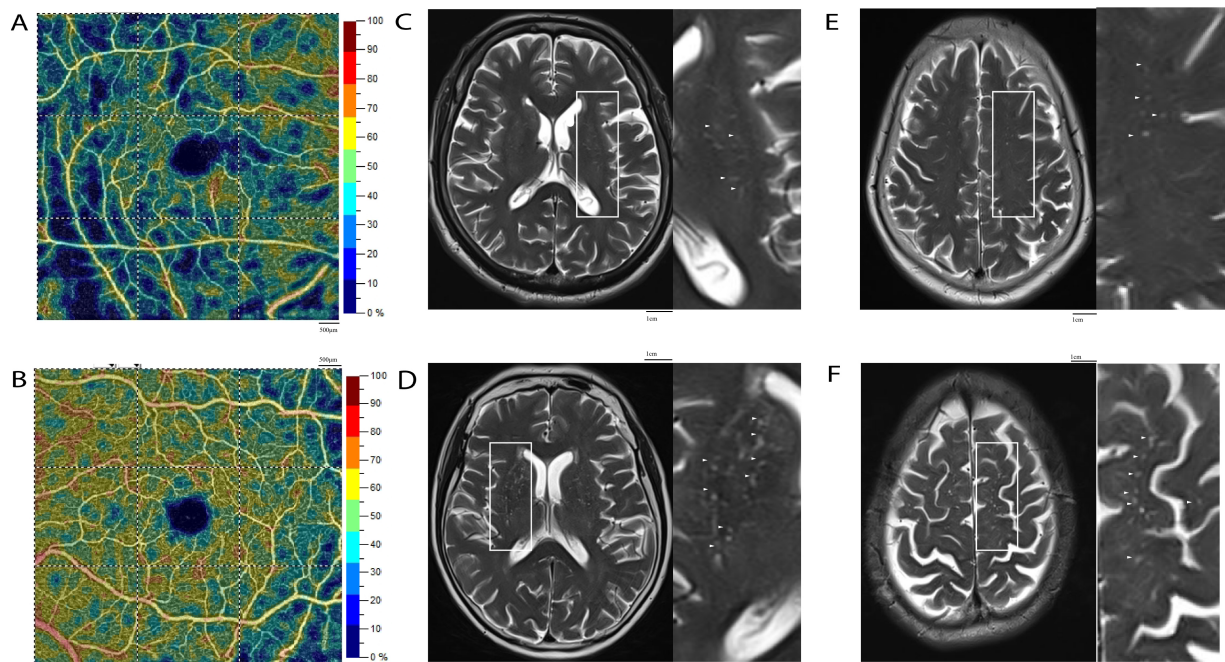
Different densities of superficial retinal capillary plexus (SRCP) and different burdens of EPVS. (A) Low SRCP density on OCTA. (B) High SRCP density on OCTA. (C) Low BG-EPVS burden. (D) High BG-EPVS burden. (E) Low CSO-EPVS burden. (F) High CSO-EPVS burden. Scale bars: 500 μm and 1cm in OCTA images (A,B); 1 cm in MRI images (C–F). Annotations: White solid boxes indicate the region of interest (ROI) for a magnified view; small white arrows point to representative EPVS.
